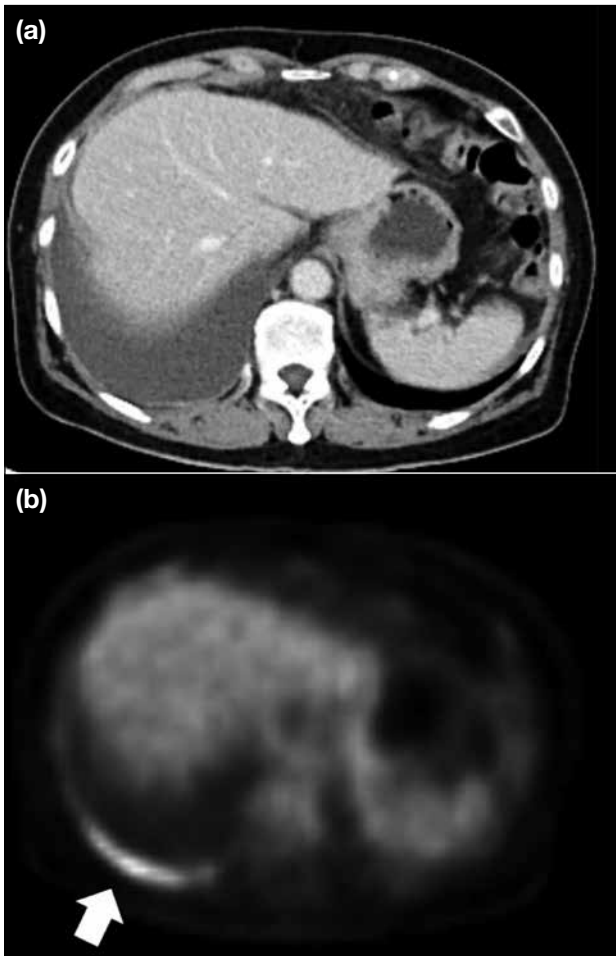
(a) Contrast enhanced computed tomography image showing right pleural effusion. (b) Positron emission tomography shows increased fluorodeoxyglucose uptake along the pleura (arrow), suggestive of metastatic deposits and stage IV disease.
